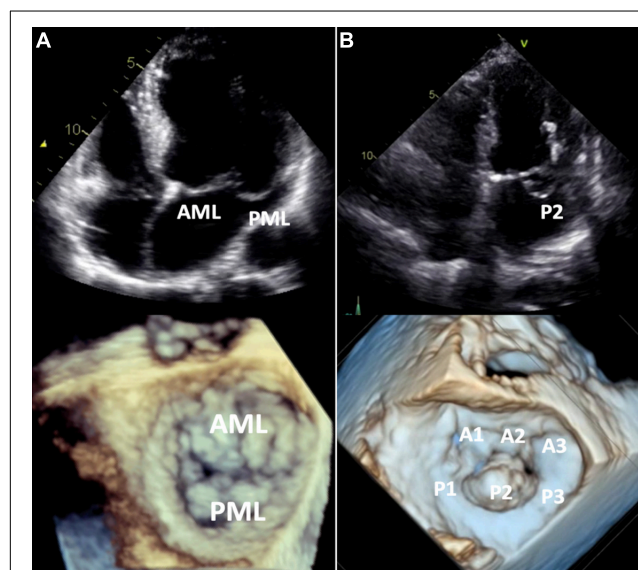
Barlow's disease vs. fibroelastic deficiency. 2D transthoracic four-chamber view (upper panels) and 3D transesophageal focused view of the mitral valve (lower panels). (A) Barlow's disease with annular dilatation, thickened leaflets and bileaflet prolapse (anterior + posterior mitral leaflet). (B) Fibro-elastic deficiency with prolapse (flail) of the P2 segment of the posterior mitral leaflet due to chordal rupture. Mitral annulus diameter is normal in this case, but mild annular dilatation can be present. AML, anterior mitral leaflet; PML, posterior mitral leaflet.
